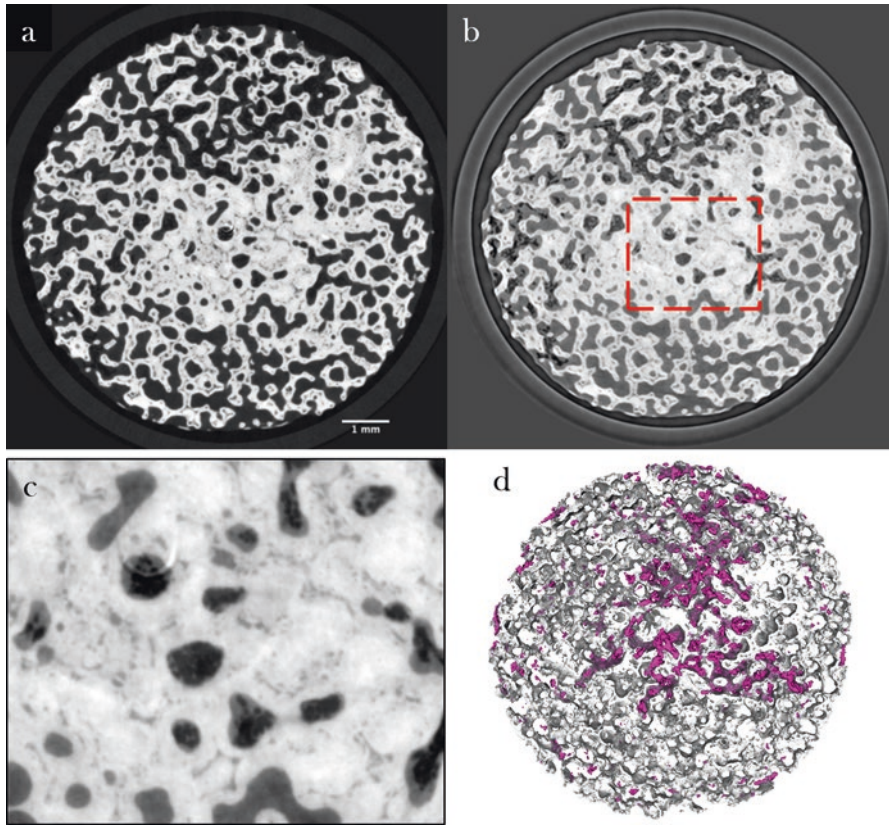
Phase μ CT imaging of mineralised scaffolds. (a) Standard μ CT image of a Skelite disk seeded with osteoblasts. (b) Phase tomogram of the same disk, showing clearly the deposited soft tissue. It can be seen that soft tissue is formed mainly inside the scaffold construct and that the volume filling fraction is high. (c) Zoom on the marked area in (b). There is sufficient contrast to segment not only scaffold and soft tissue but the osteocytes as well. (d) Rendering of the scaffold and the segmented osteocytes
